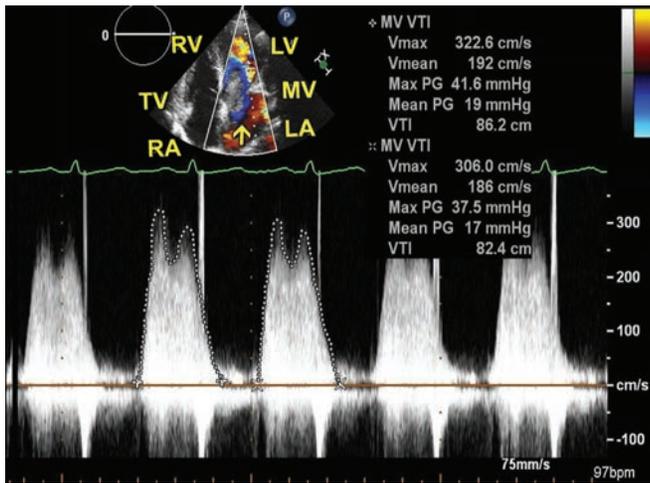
Continuous wave Doppler through mitral valve inflow.
